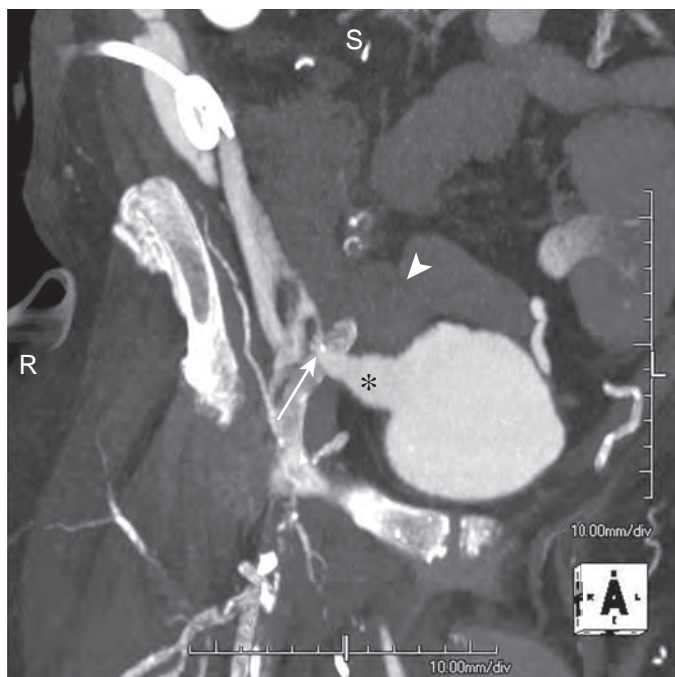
Anastomotic leak at the duodenocystostomy in a 53-year-old man 17 years after SPK transplantation with systemic venous–bladder drainage. Retrograde CT cystogram demonstrates leakage from the lateral margin of the duodenocystostomy (asterisk) adjacent to the duodenal suture line (arrow). The pancreas transplant (arrowhead) is more difficult to visualize because of lack of intravenous contrast material. Note the percutaneous pigtail drain in the right lower quadrant. (From Vandermeer F, Manning MA, Frazier A, et al: *Imaging of whole-organ pancreas transplants*. *RadioGraphics* 32:411–435, 2012.)
